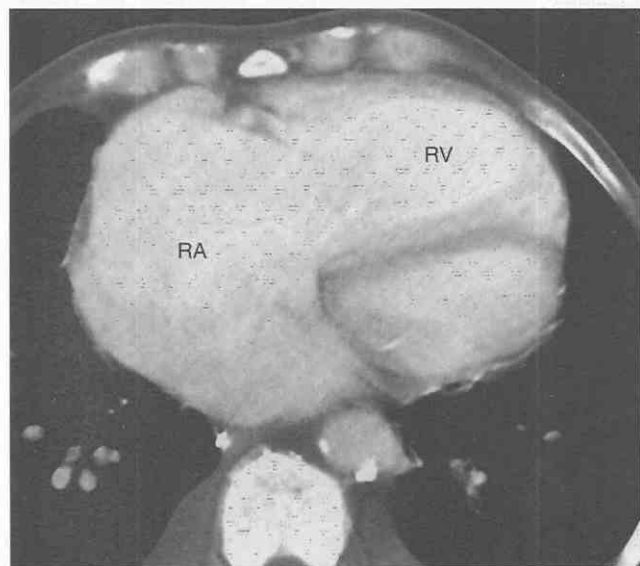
Atrial septal defect. Axial CT with intravenous contrast medium shows marked enlargement of both the right atrium (RA) and the right ventricle (RV) in this patient with atrial septal defect documented by echocardiography.
